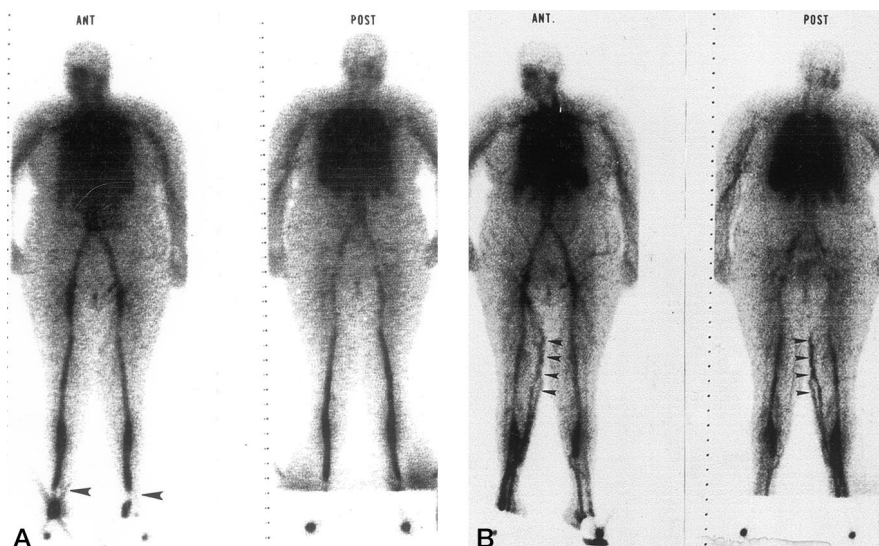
A normal result in a 61-year-old woman with acute onset of swelling and redness in her left calf. (A) The whole-body anterior and posterior body images were obtained during the first pass with tourniquets applied at the ankles (arrowheads). Patent popliteal, femoral, and iliac veins are visualized. (B) The second-pass images after release of the tourniquet show the greater saphenous vein along the medial aspect of the right lower extremity (arrowheads). Doppler ultrasound showed no evidence of thrombosis.
